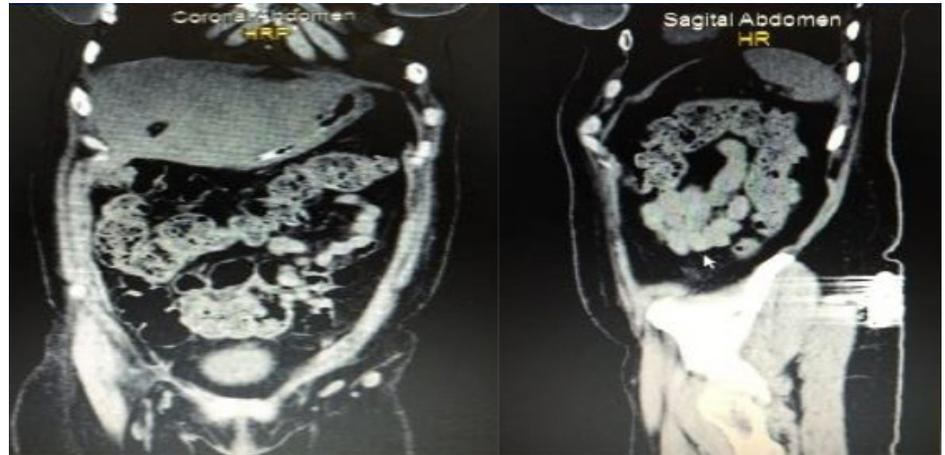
CT-SCAN Abdomen with evident anatomic variations.
